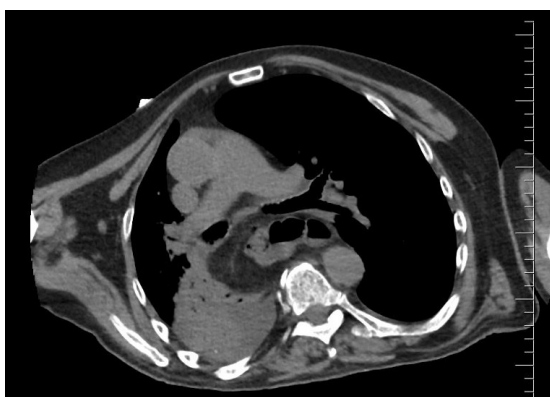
Chest CT-scan revealing a huge heterogeneous tumour at posterior mediastinum.
